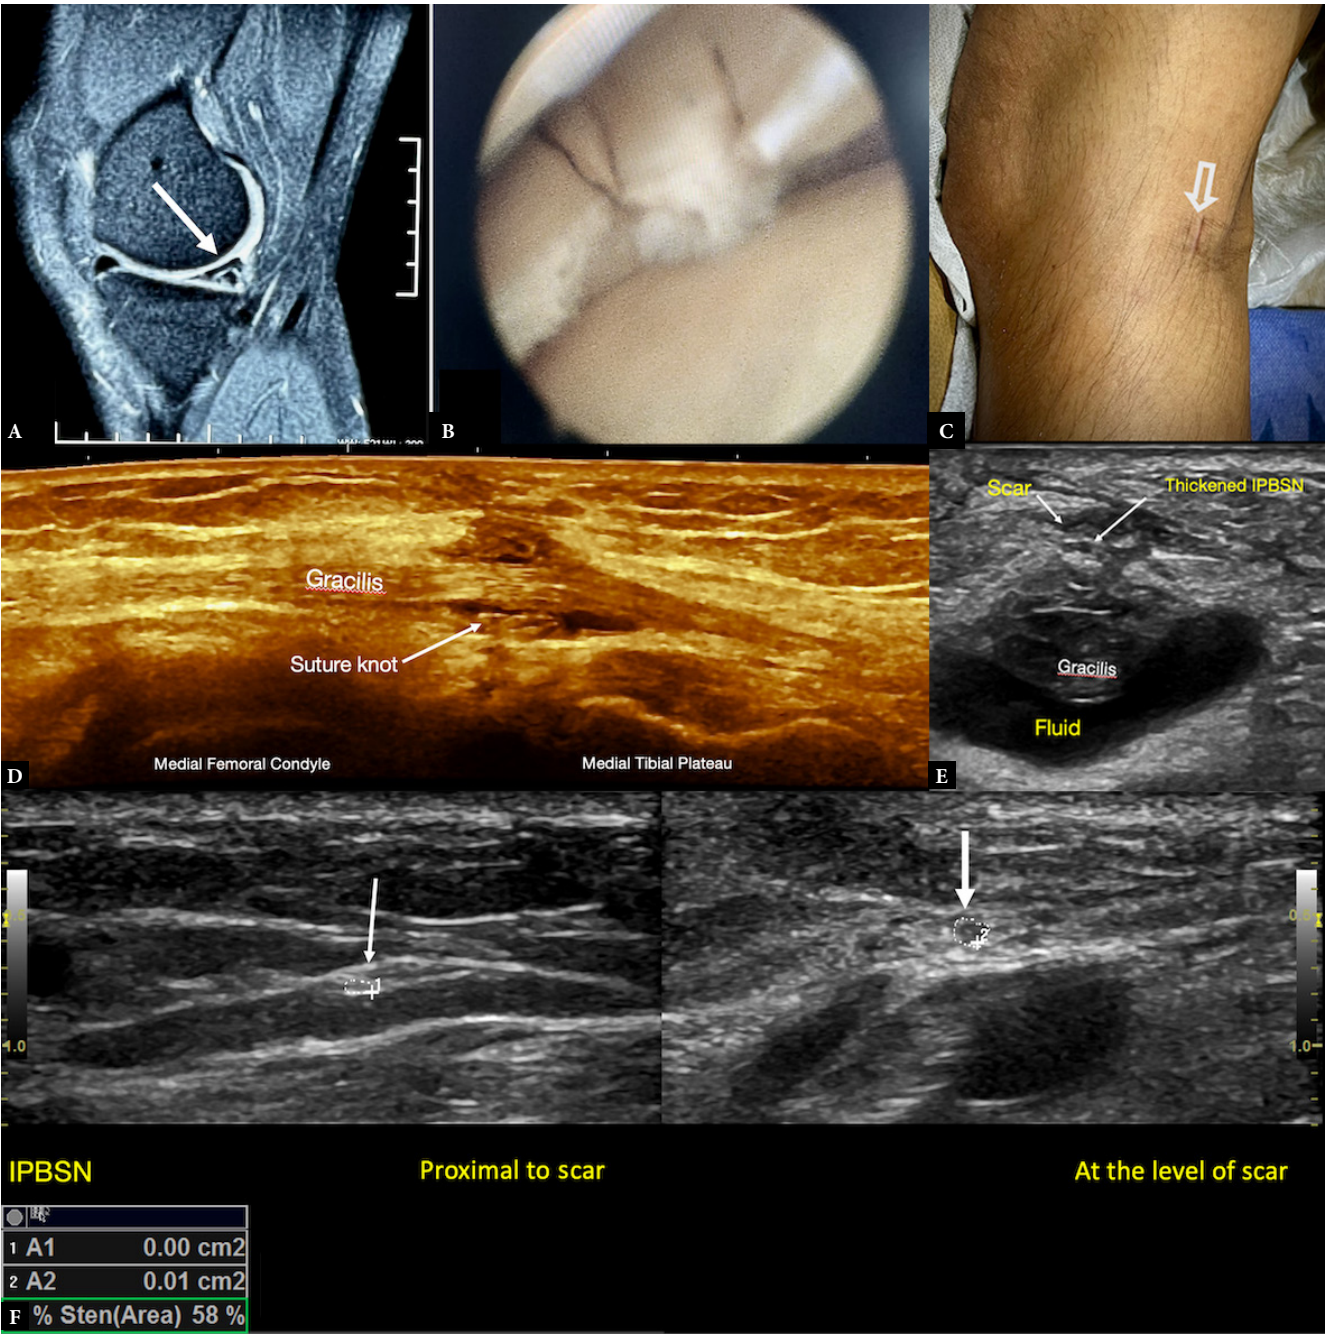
Infrapatellar branch of the saphenous nerve (IPBSN) injury following medial meniscal repair surgery. A. Proton-density fat-suppressed sagittal MRI image showing an oblique tear in the posterior horn of the medial meniscus B. Arthroscopic image of the torn meniscus C. Scar site corresponding to the site of the ultrasonographic Tinel sign D. Longitudinal view at the scar site revealing a suture knot around the gracilis muscle E. Transverse view across the scar site showing a thickened IPBSN adjacent to the scar, overlying the gracilis muscle F. Cross-sectional area of the nerve (arrow) measured proximal and at the scar site shows focal enlargement with increased hypoechogenicity of the nerve at the scar site consistent with neuroma formation. The IPBSN was traced for its origin from the saphenous nerve; in this patient, it followed a more posterior course than usual. IPBSN – infrapatellar branch of the saphenous nerve
